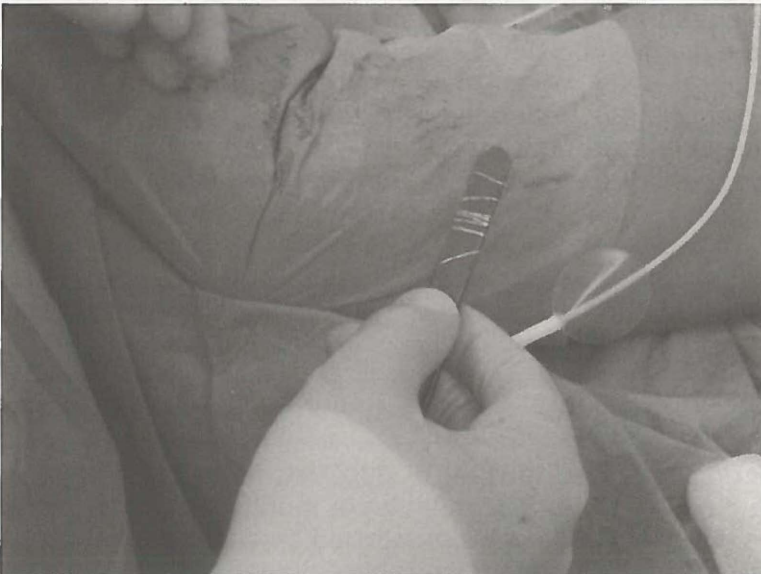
The wire of the implantable Doppler system is being coiled around a forceps to ensure that, after inset of the flap, tension on the external wire is not being transferred directly to the junction between the wire and the silicone cuff.
